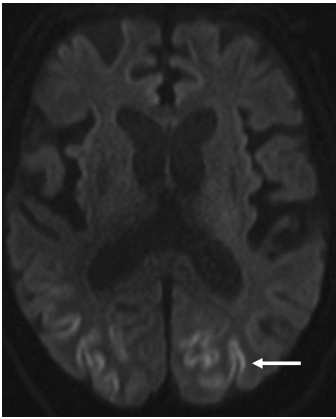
Hypoglycemic encephalopathy. On this b1000 DWI sequence, thin cortical hyperintense restricted diffusion is seen within the occipital lobes (*arrow*), extending into the posterior parietal lobes. (Corresponding ADC hypointensity indicated true restricted diffusion; not shown.)
